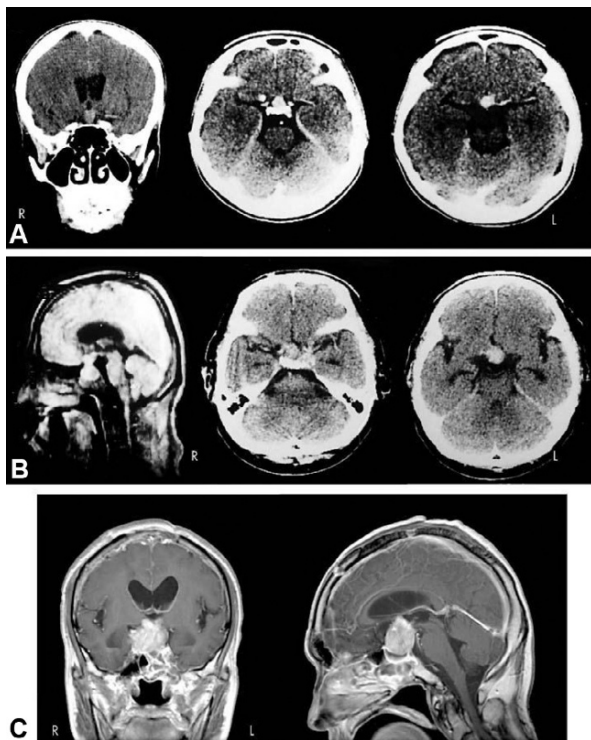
Brain imaging of a pituitary adenoma that extended to the hypothalamus. (A) Brain computed tomography (CT) scans of case 1 (coronal and axial planes with contrast enhancement) showed a pituitary tumor extending upward to the hypothalamus and compressing the hypothalamus, optic chiasm, stria terminalis, septal area, and supraoptic area. (B) Magnetic resonance imaging (MRI) scan (sagittal plane, proton-weighted image) and CT scans (axial plane with contrast enhancement) of case 2 showed a similar-sized pituitary tumor. (C) MRI scans of case 3 (coronal and sagittal planes, gadolinium-DTPA images) showed a pituitary tumor extending upward to the third ventricle and compressing the hypothalamus bilaterally. (Reproduced from Yamamoto et al., 2005.)
